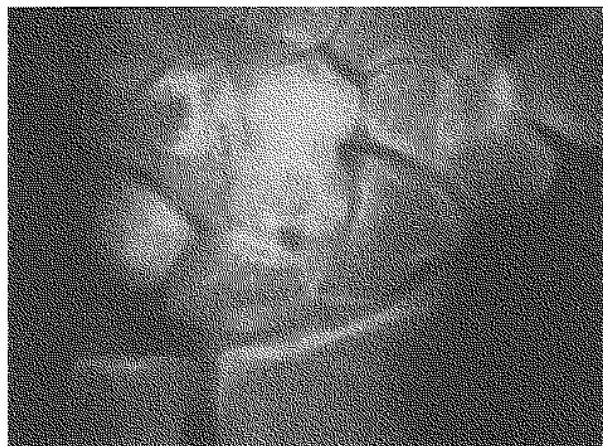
Xray film showing a sclerotic area and small cystic changes in the body of the capitate.
